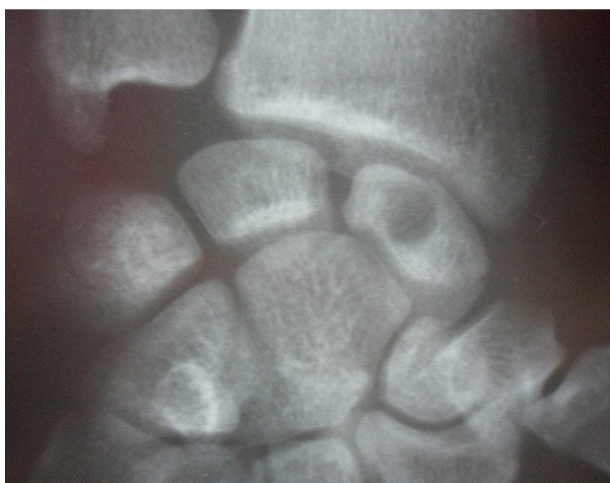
Plain radiographs of the right wrist revealed a round-shaped radiolucent lesion of the scaphoid with a thin marginal sclerosis and a pathological fracture
